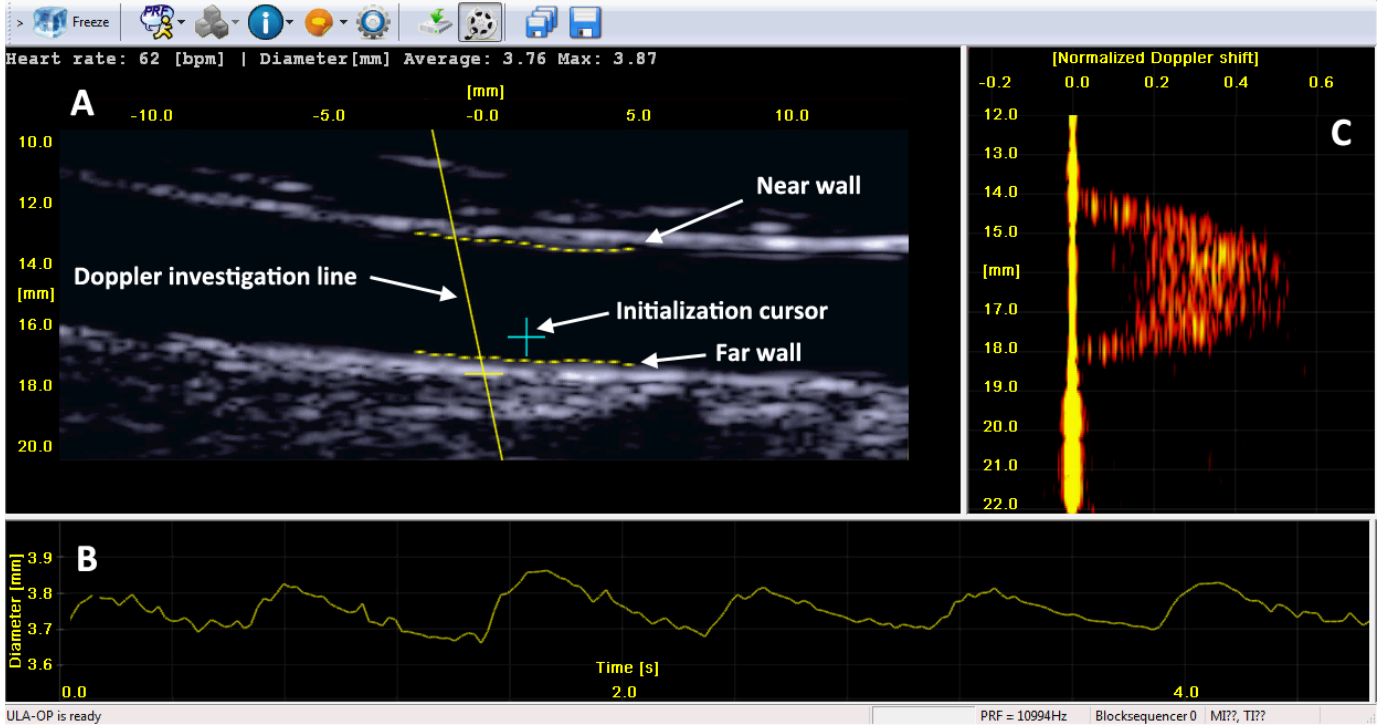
The ULA-OP software interface during an exam on the brachial artery of a healthy volunteer. The interface shows in real-time: (A) the B-mode images, including the near and far wall markers (dotted yellow lines) calculated by the edge-detection algorithm; the diameter trend (B); and (C) the multi-gate spectral Doppler profile (with depth on vertical axis, Doppler shifts on horizontal axis and local power spectral Doppler densities modulating the pixel intensities), obtained along the Doppler investigation line (solid yellow line in panel A).
